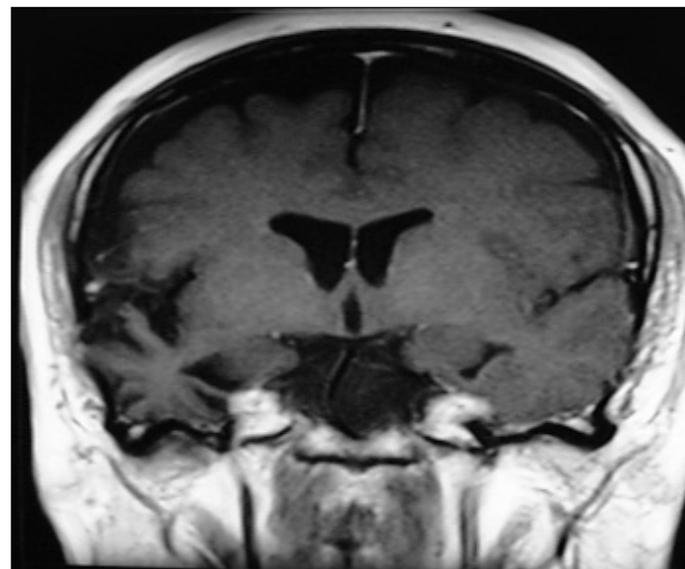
T1-weighted frontal image revealed atrophy in the right temporal lobe.
